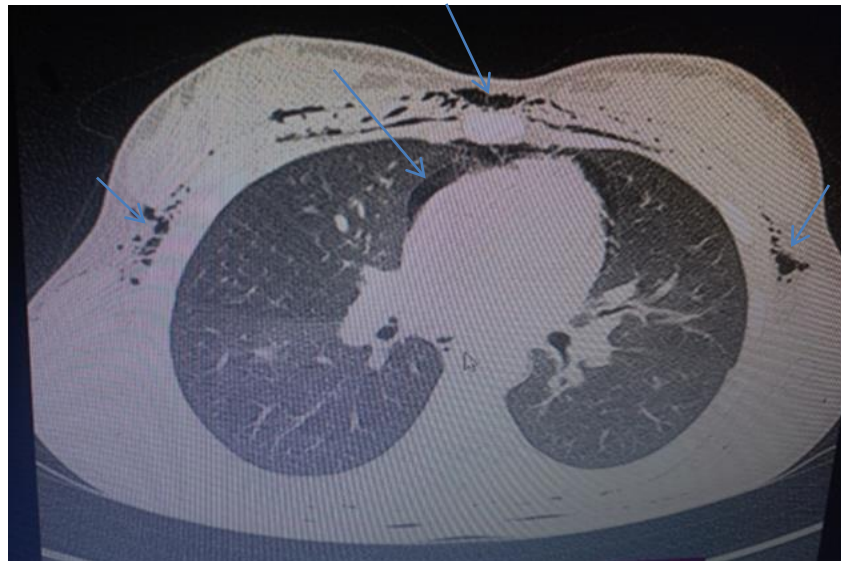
Axial View chest CT scan showing pneumomediastinum and subcutaneous emphysema
